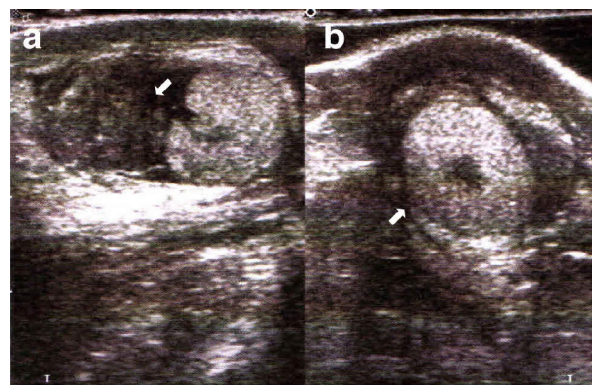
Ultrasonography scans of the scrotum and left testicle. a - a multilobed heterogeneous structure the topography of the upper third of the scrotum, suggesting it is a twisted and thickened spermatic cord. b - diffused increase of the echogenicity of the testicle.
